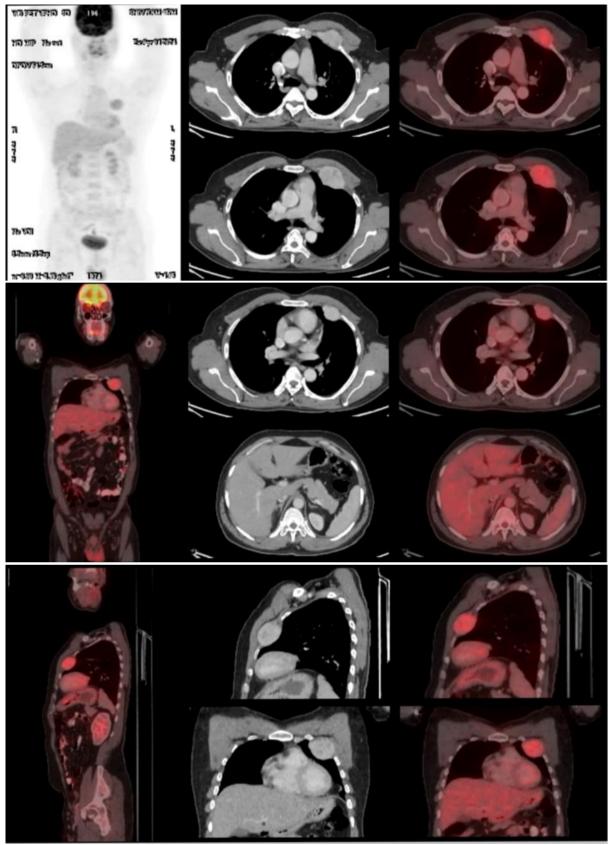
A positron emission tomography (PET) scan reveals a variably enhancing soft tissue mass that causes erosive changes in the left third rib and the adjacent third costochondral junction (SUVmax - 4.2; dimensions 4.9 x 3.3 x 4.3 cm). This mass is situated close to the medial ends of the left pectoralis minor and major muscles at the front, as well as the costal pleura of the left upper lung at the back, as shown in the axial and coronal view sections.
